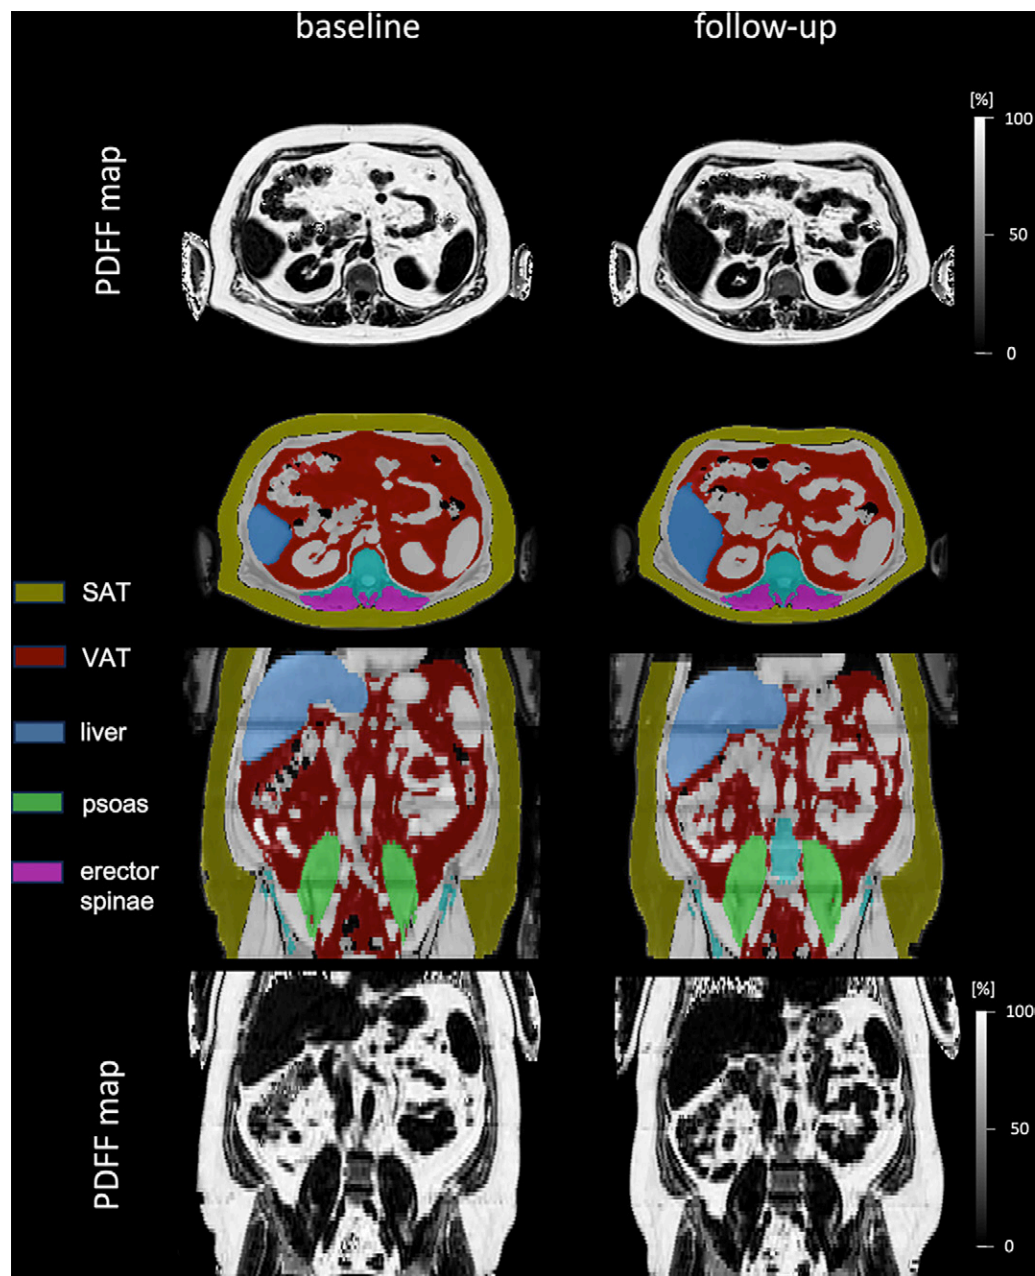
Axial and coronal view of MRI-based proton density fat fraction (PDFFF) maps and corresponding organ segmentations in a male participant (age at baseline, 43 years; body mass index [BMI; calculated as weight in kilograms divided by height in meters squared] at baseline, 38.8 kg/m²) before and after the weight loss intervention. The participant lost 14.8 kg (from 147.5 kg to 132.7 kg) and decreased his BMI by 3.9 kg/m². The decrease in visceral adipose tissue (VAT) volume from 11.55 L to 8.32 L can be detected visually. SAT = subcutaneous adipose tissue.
